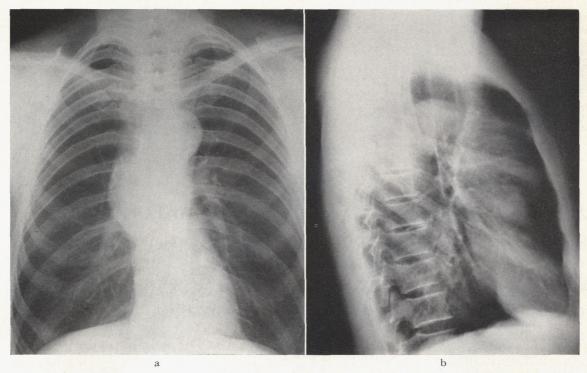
a, Posterior anterior roentgenogram of chest showing aneurysm arising in ascending aorta, the right lateral margin of which is outlined by flecks of calcium; b, lateral projection suggests involvement of transverse arch.
